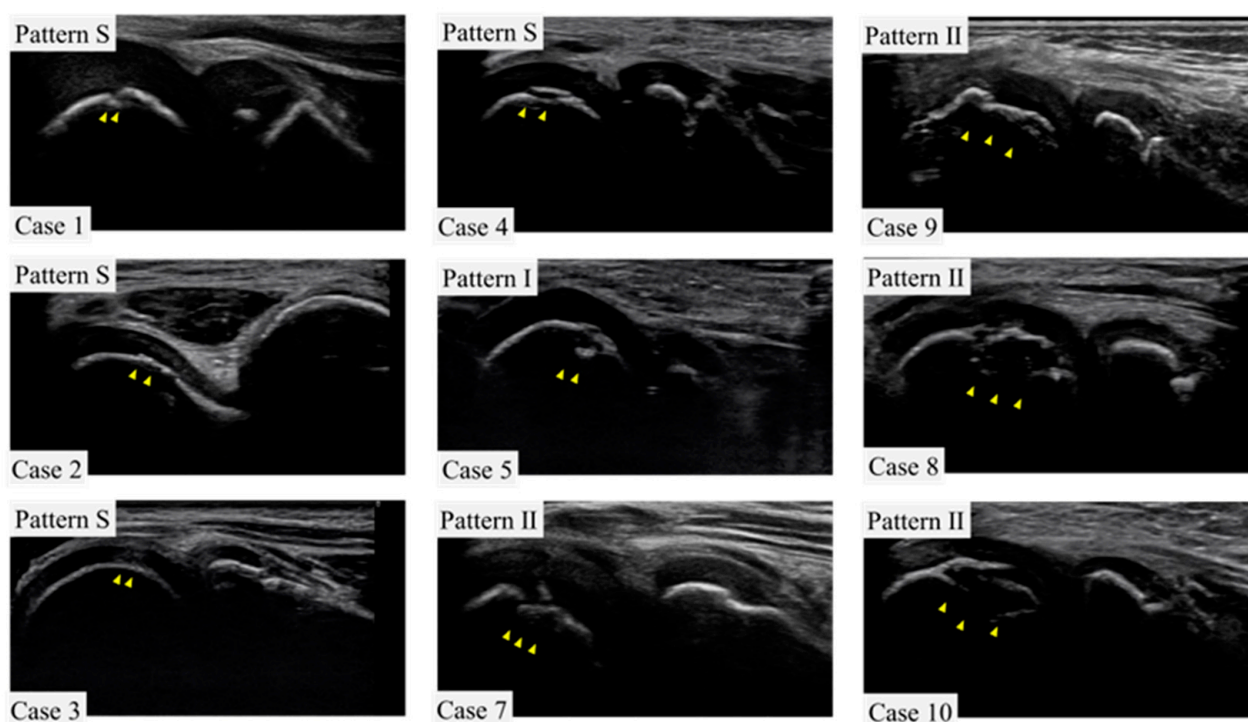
Ultrasound images of the lateral elbow for each case in this study. For one case (case 6), only the record was available, and the image was not preserved. Arrowheads indicate sites of OCD.
